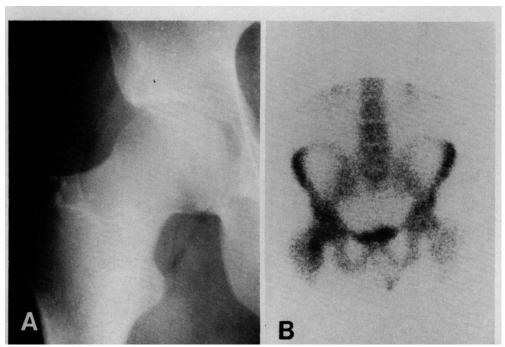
A, compression-side femoral neck stress fracture but a normal radiograph. B, same patient with positive compression-side stress fracture bone scintigraph.
